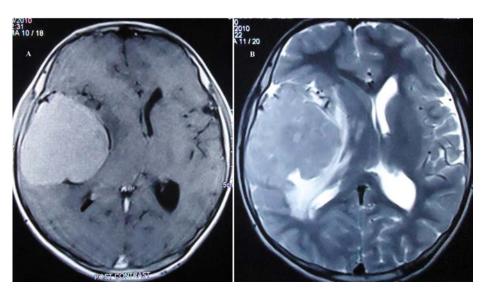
T1 weighted MR image of atypical meningioma after contrast showing a contrast-enhancing tumor with midline shift (A). T2 weighted image showing perilesional edema (B).
